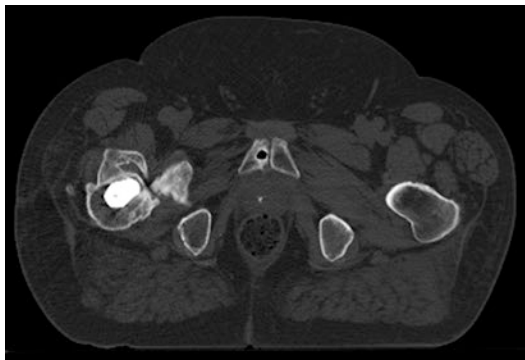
Axial CT cut at the level of lesser trochanter revealing significant heterotopic ossification about the right hip
